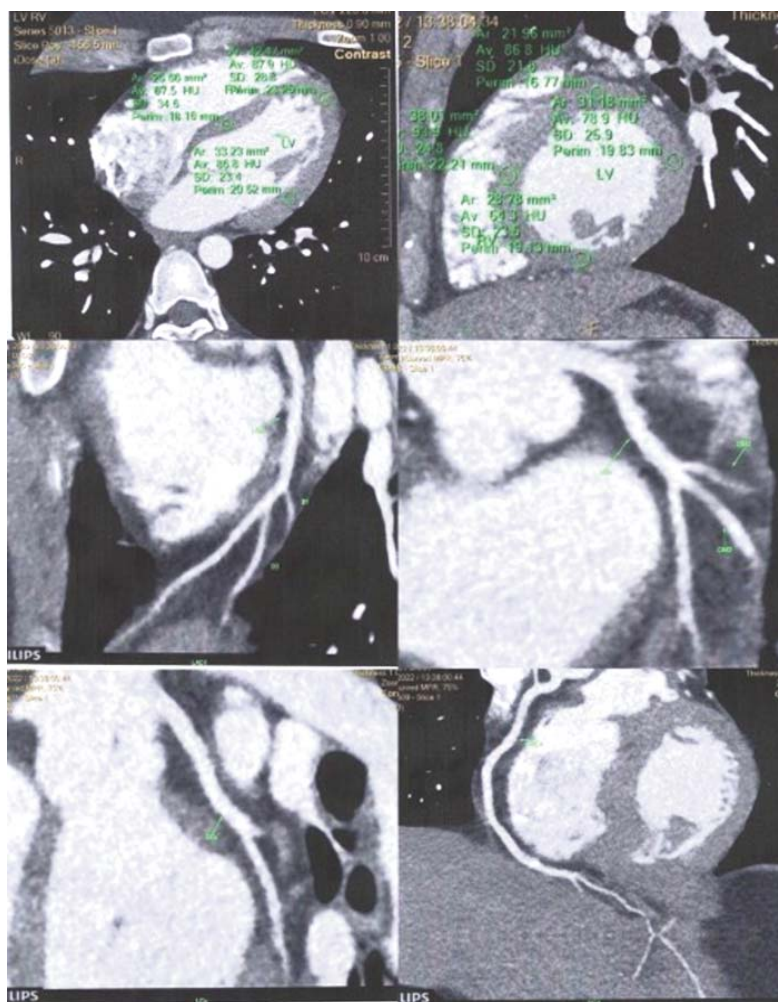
Cardiac CT-Scan after 24 hours.
